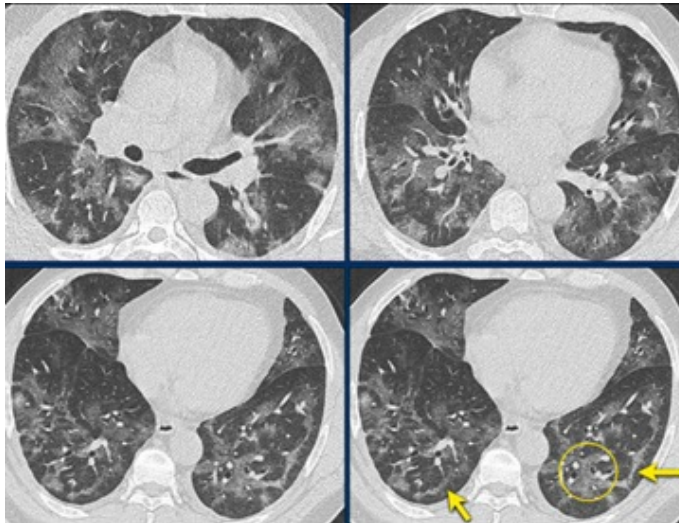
A 49-year-old male presented with fever and cough. His oxygen saturation was low on pulse oximetry. On CT, bilateral GGOs, the fibrotic band (indicated with arrow, dilated vascular structure in the involved area (circle) were evaluated as COVID-19 late phase finding.
